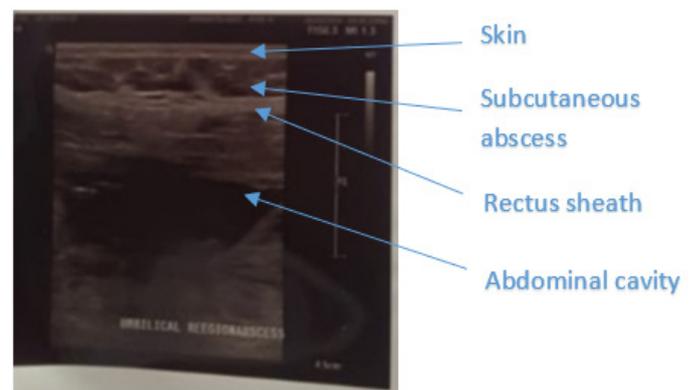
Ultrasound showing a cutaneous incisional abscess within the surgical site.
